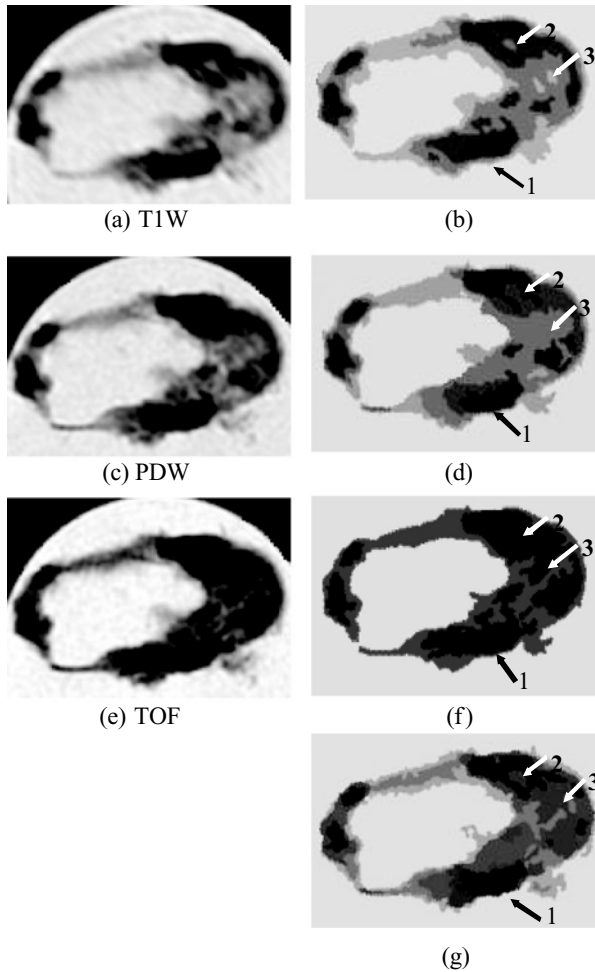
An example of MCW MR image segmentation. (a), (c), (e) The original contrast weighting images at the same location. (b), (d), (f) The corresponding single contrast weighting segmentations. (g) (color) Result with the proposed multiple contrast weighting segmentation algorithm.
